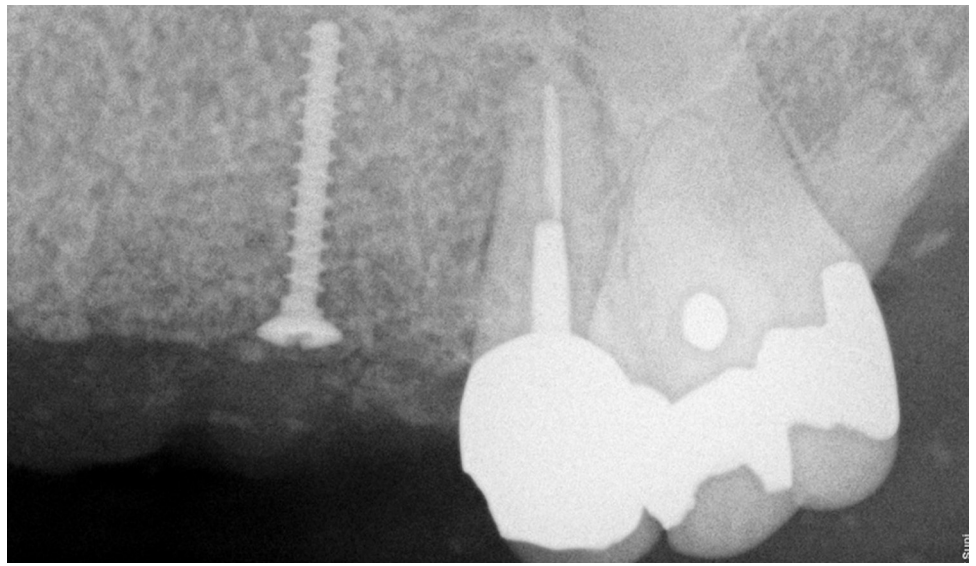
Radiograph of lateral maxillary surgical site four months after guided bone regeneration surgery. New bone growth was noted up to seven threads on the posterior tenting screw.
